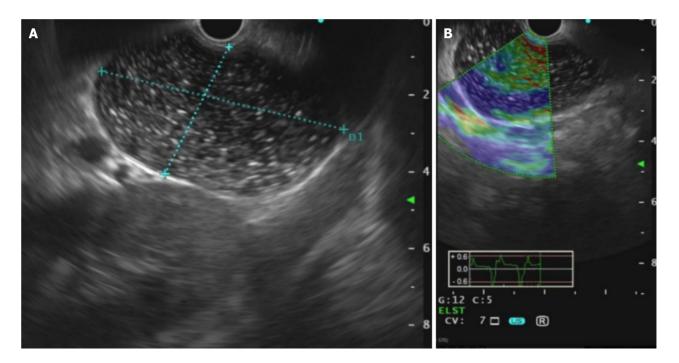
Imaging at admission. Endoscopic ultrasound revealed a 6.5 cm × 4.0 cm single cyst. The cyst, without any echoes or color flow signals, was located in the posterior wall of the gastric body. These results indicated the possibility of a cyst of the stomach.
